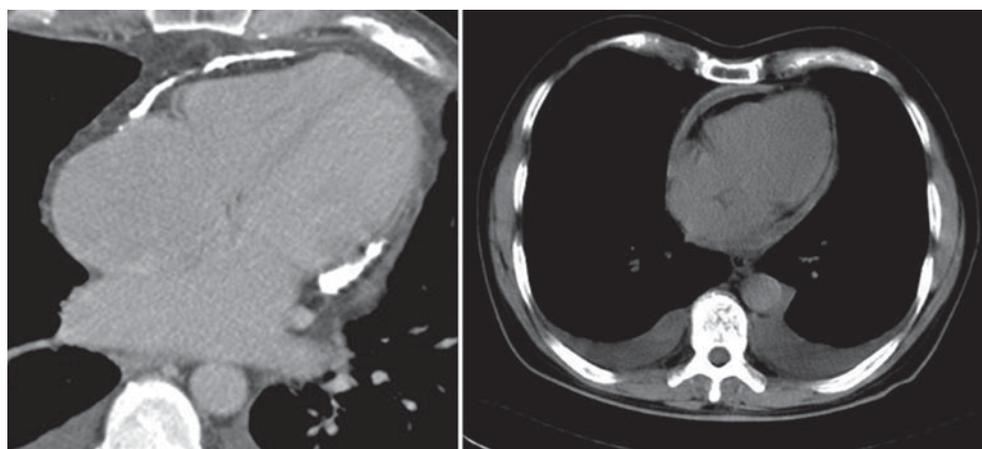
Two CT scans of patients with constrictive pericarditis. On the left, several calcifications (high signal intensity) can be seen; on the right, the pericardium is severely thickened
